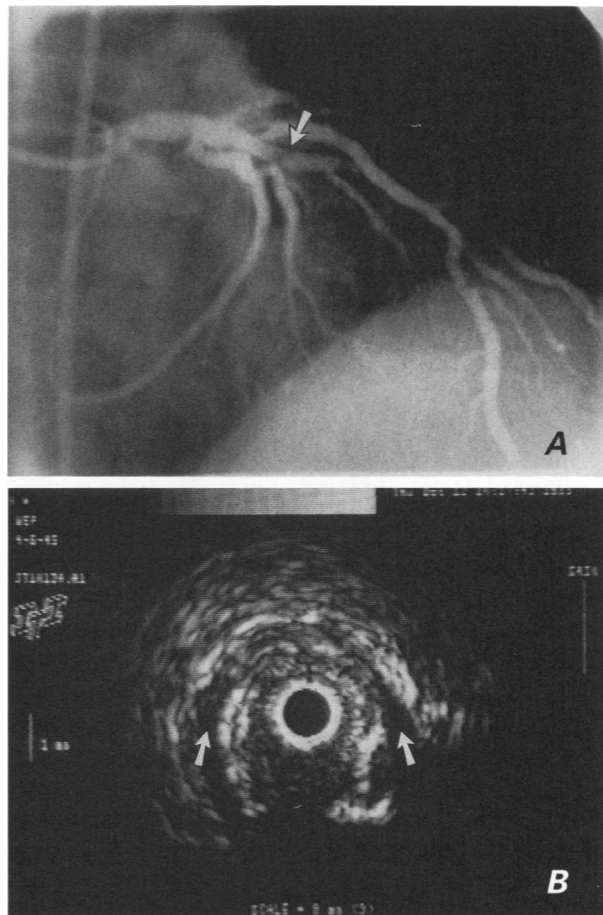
After initial balloon dilation, this left anterior descending coronary artery at angiography (A) exhibits a residual haziness at the level of the dilation (arrow), despite complete inflation with a 4.0-mm balloon. Subsequent unsuccessful dilations led to ultrasonic investigation (B), which revealed dissection and separation between the internal elastic membrane and the media (arrows). The portion of the lumen just below the central catheter circle is not completely echolucent because it is filled with a large residual atheroma or thrombus which corresponded to the hazy section on angiography.
